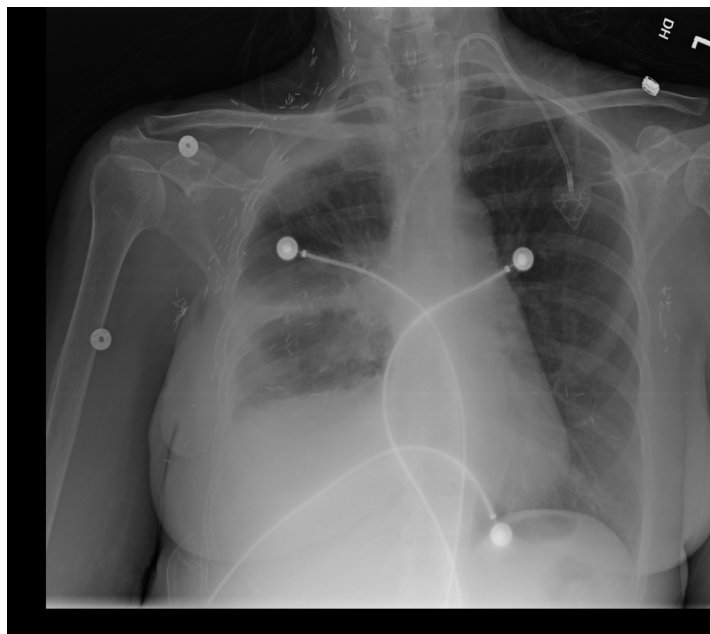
Chest x-ray four weeks after IPC insertion. Resolution of hydropneumothorax with repositioning of the right hemidiaphragm and minimal residual pleural fluid.
